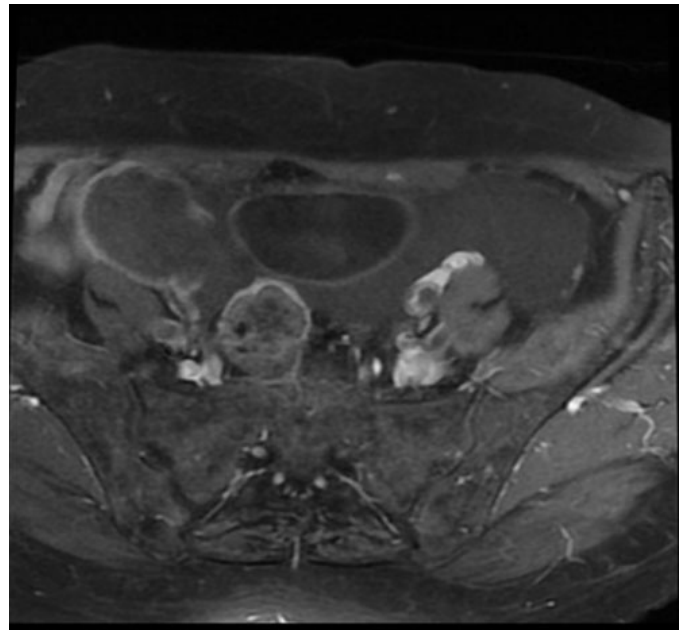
T1-weighted axial MRI after gadolinium injection, showing contrast enhancement of the cystic wall of the ruptured appendicular mucocele at the level of the right iliac fossa and open in the large peritoneal cavity with moderately abundant ascites.
